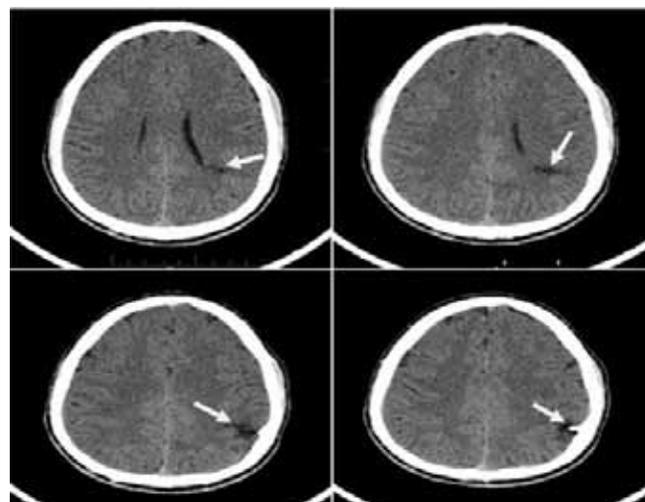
CT scan brain showing cleft in the parietal lobe extending from left lateral ventricle to pial surface suggestive of closed lip schizencephaly.
